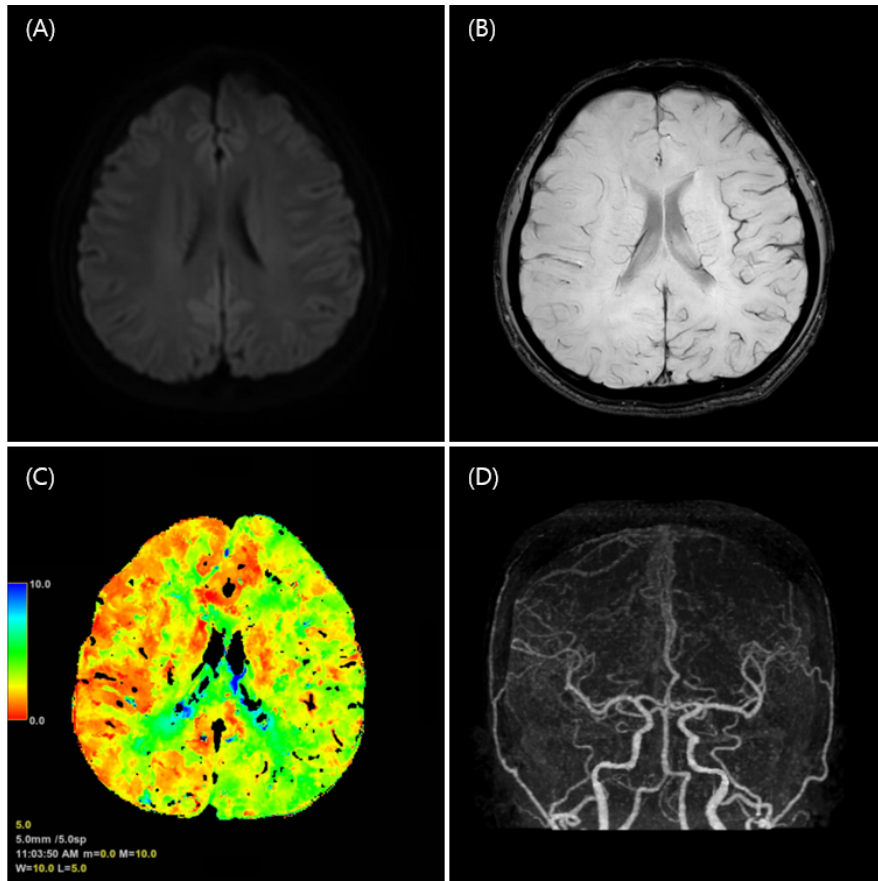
In the left hemisphere, restricted lesions are seen on DWI (A) and a prominence of cerebral veins on SWI (B). CT perfusion revealed subtle delay and decreased cerebral perfusion in the same lesion (C), while MR angiography was normal (D).
